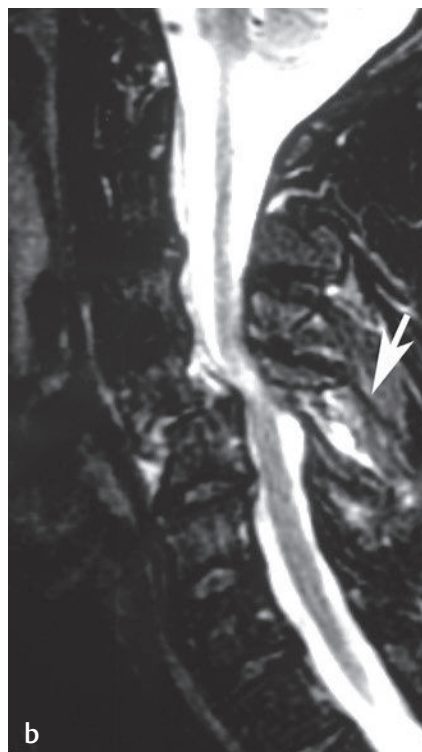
A discoligamentous complex injury. (a) A lateral radiograph shows bilateral facet subluxation at C4-C5, with widening of the interspinous process space (between *arrowheads*). (b) A sagittal STIR image shows edema in the region of the interspinous and supraspinous ligaments between C4 and C5 (*arrow*), which is compatible with injury to the discoligamentous complex. (From Khanna AJ, Kwon BK. Subaxial cervical spine injuries. In: Rao RD, Smuck M (eds). Orthopaedic Knowledge Update: Spine 4. Ed 4. Rosemont (IL): American Academy of Orthopaedic Surgeons, 2012:221–233. Reprinted by permission.)
